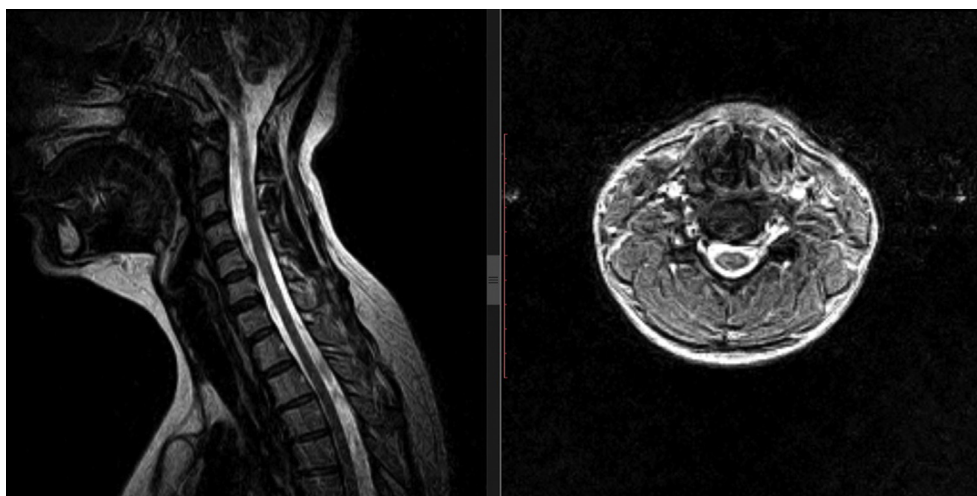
Preoperative MRI demonstrating herniated disc at C5-6.
